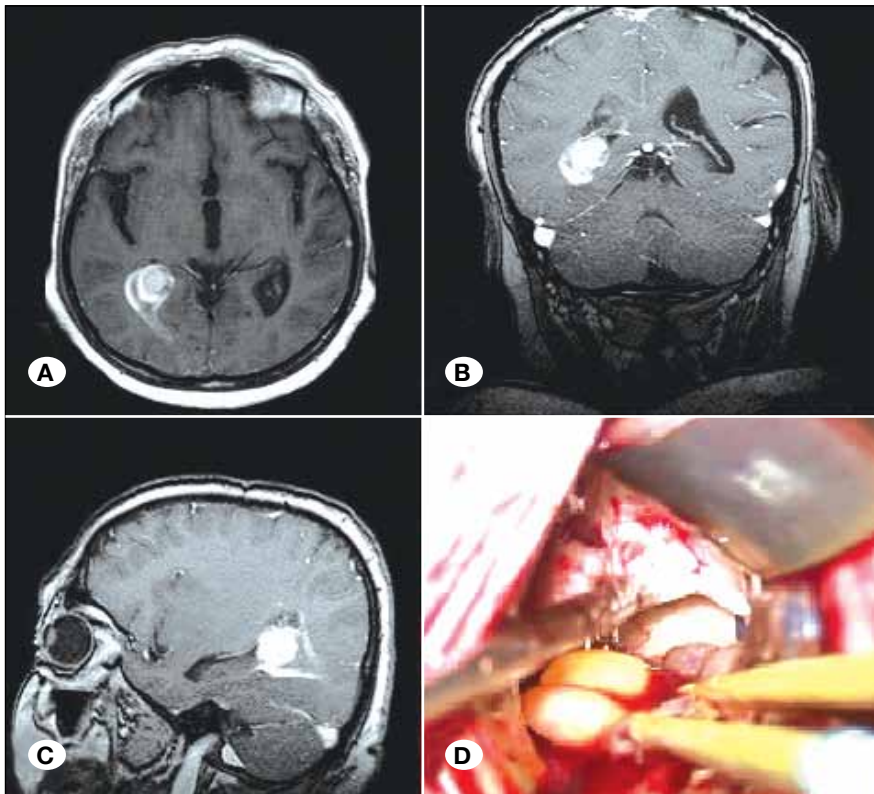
Preoperative axial (A), coronal (B) and sagittal (C) MR images show a hyperintense contrast-enhancing mass lesion in the right atrium. The lesion was removed via POIPA (D) and the diagnosis was choroid plexus papilloma.
